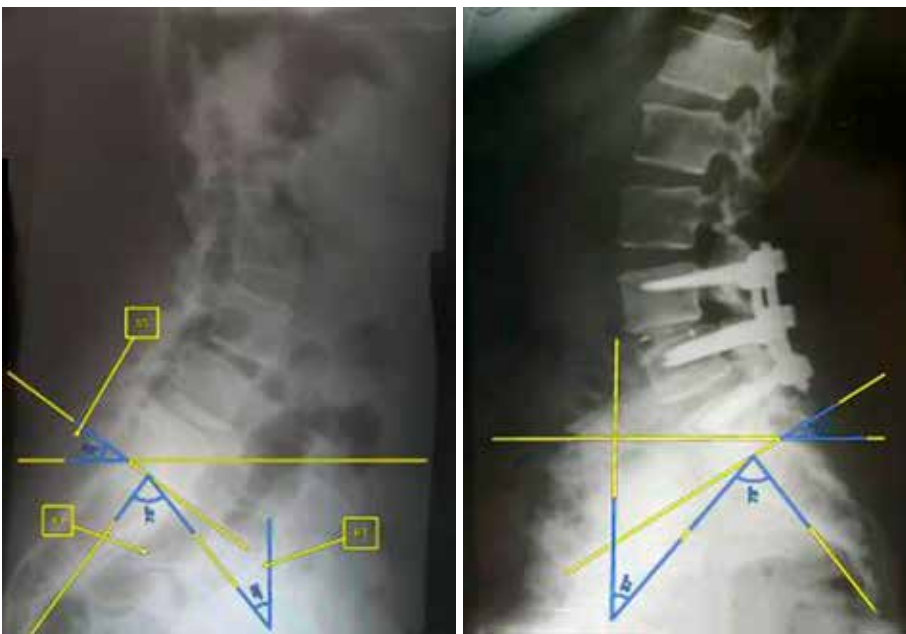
Radiographic control before and after surgery using the traditional minimally invasive posterior interbody vertebral stabilization (MIPIVS) technique
